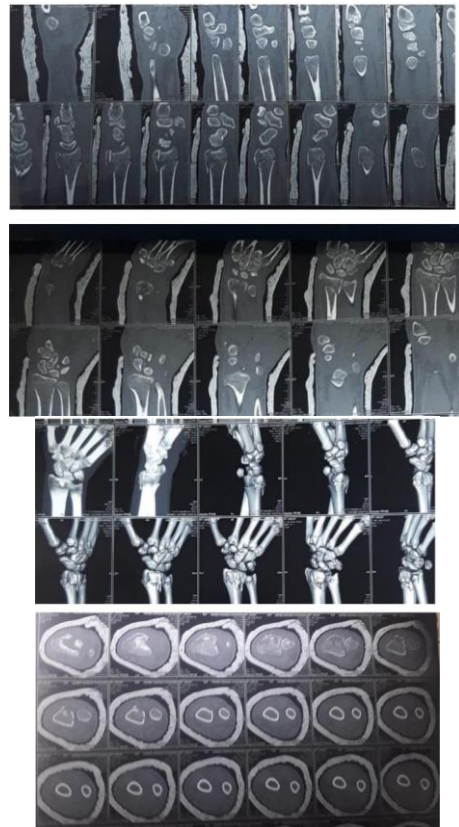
Post-reduction CT scan cuts.
